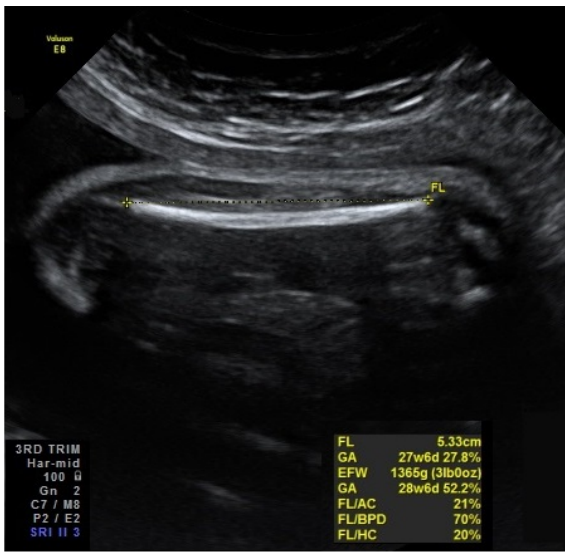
B-mode Ultrasound Image of Fetal Femur from a Clinical Study*
